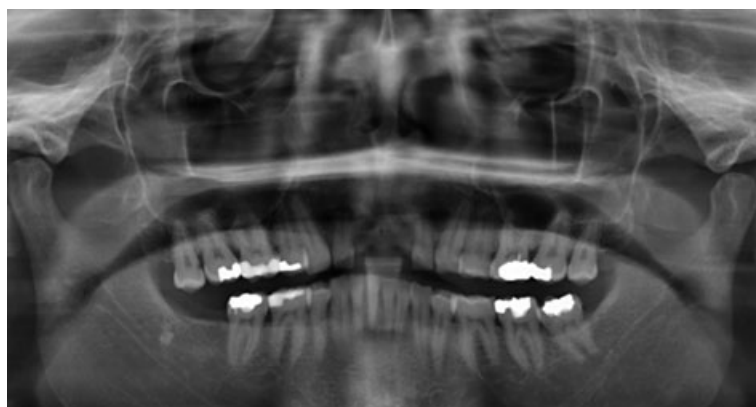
Pre operative panoramic xray.
